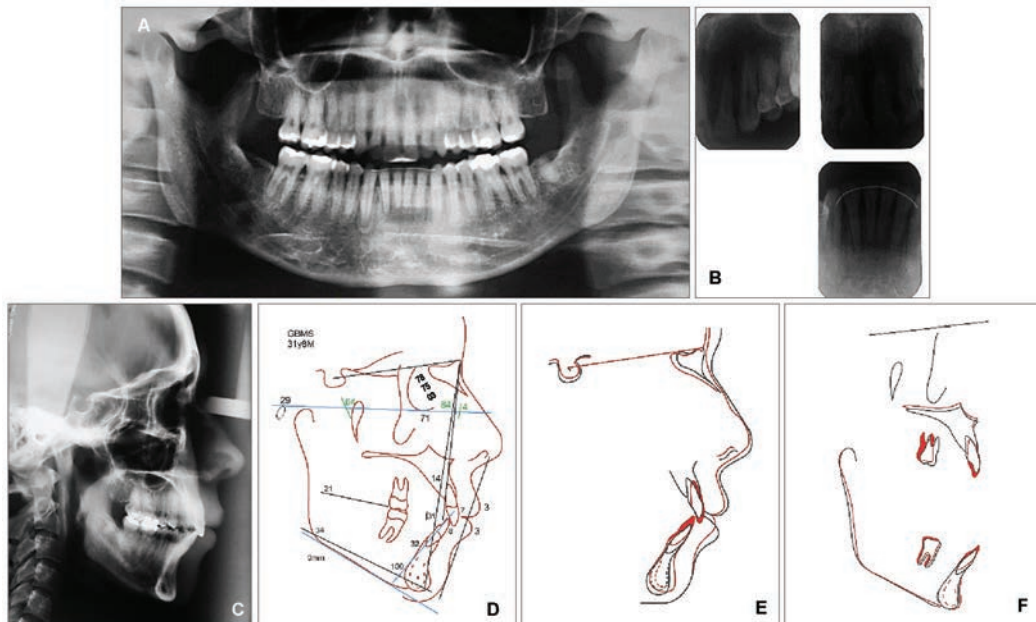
X-rays: panoramic (A); periapical (B) and final cephalometric (C). Final cephalometric tracing (D). Overlaps: N recorded (E), best-fit of maxilla and internal contour of mentonian symphysis (F).
